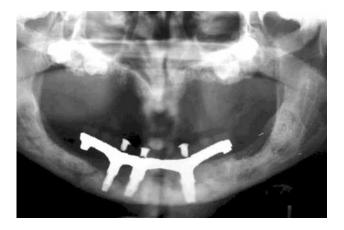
Radiographic aspect of the metal-reinforced mandibular prosthesis.
